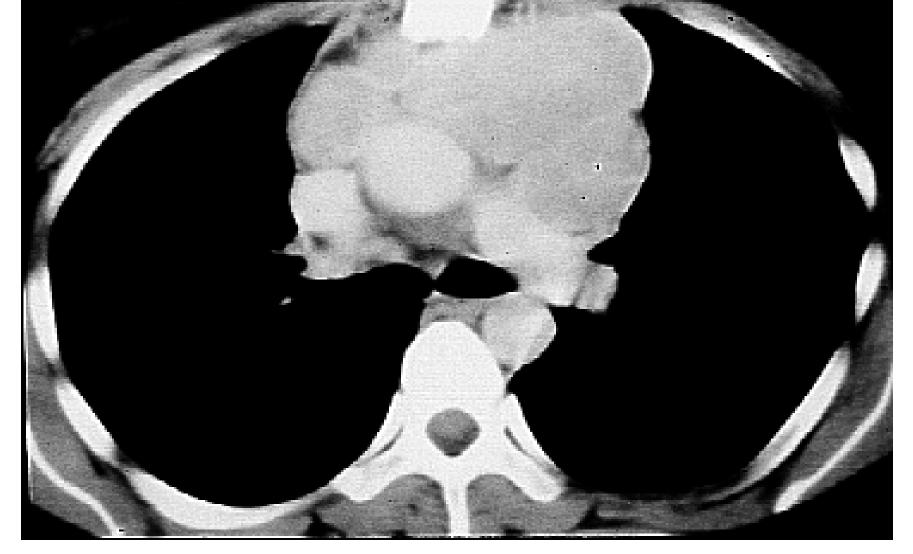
Windowing the thorax. Chest CT scans are usually "windowed" and displayed in several formats in order to optimize anatomic definition. Lung windows (A) are chosen to maximize our ability to image abnormalities of the lung parenchyma and to identify normal and abnormal bronchial anatomy. Mediastinal windows (B) are chosen to display the mediastinal, hilar, and pleural structures to best advantage. Bone windows (C) are utilized as a third way of displaying the data, visualizing the bony structures to their best advantage. It is important to recognize that the displays of these different windows are manipulations of the data obtained during the original scan and do not require rescanning the patient.
